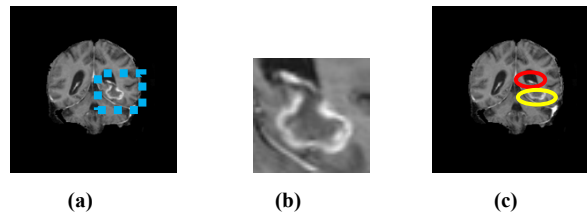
The misclassified MRI scan 536_45 of IBSR (536_T1) dataset, (a) Original MRI slice 22 with tumour inside the marked blue Square, (b) Zoomed in marked area, and (c) Misclassified blocks, where the red circle indicates wrongly classified blocks and yellow circle represents the tumour area
